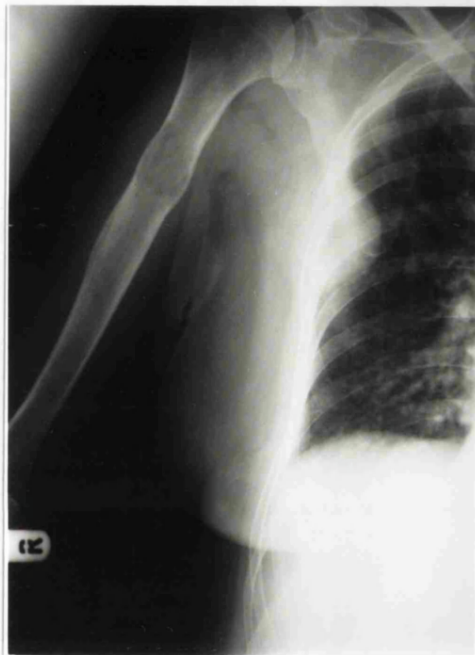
Antero-posterior radiograph showing lytic deposits in right humerus and soft tissue metastasis in right lateral chest.
